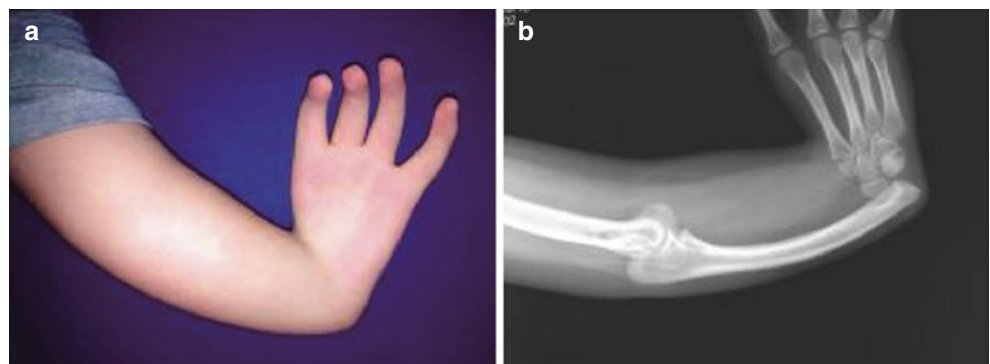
Right radial club hand. (a) Hand appearance. (b) X-ray findings
